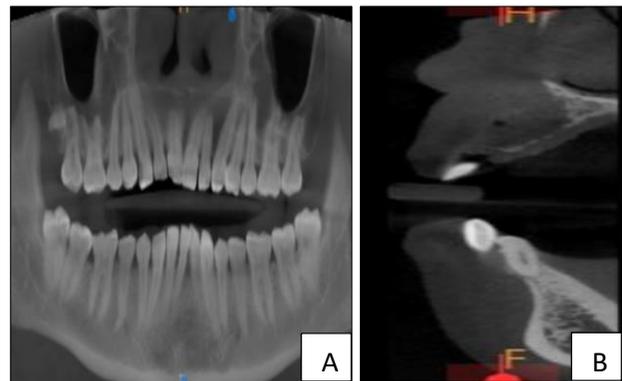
(A and B): Post-op CBCT scan panoramic view and paraxial view reveals that the radio-opaque lining of the cyst has disappeared.
